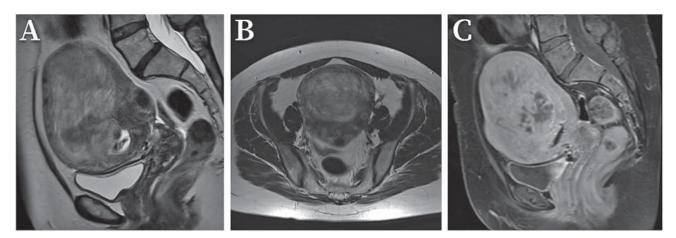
Preprocedural MRI of a 45-year-old woman complaining of irregular menstrual cycle. Sagittal and axial T2-weighted MR image (A, B) showing a large submucosal fibroid that is  $\geq$  50% intramural (FIGO classification 2) of volume 259 cm<sup>3</sup>. Sagittal post-contrast T1-weighted image with fat saturation (C) showing typical contrast opacification of the fibroid.
